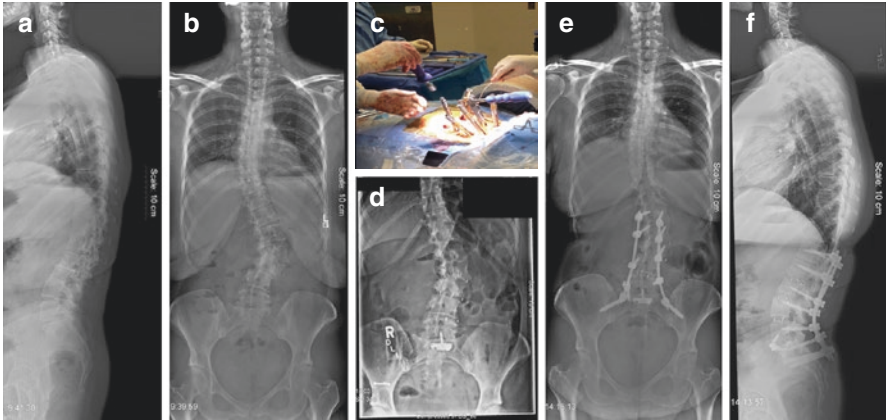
AP (a) and lateral (b) radiographs of a 45-year-old female who presented with right leg pain. She elected to undergo a two-stage LLIF and posterior spinal fusion. Positioning in the OR (c). Postoperative radiographs after the first stage (d) and the second stage (e, f)
